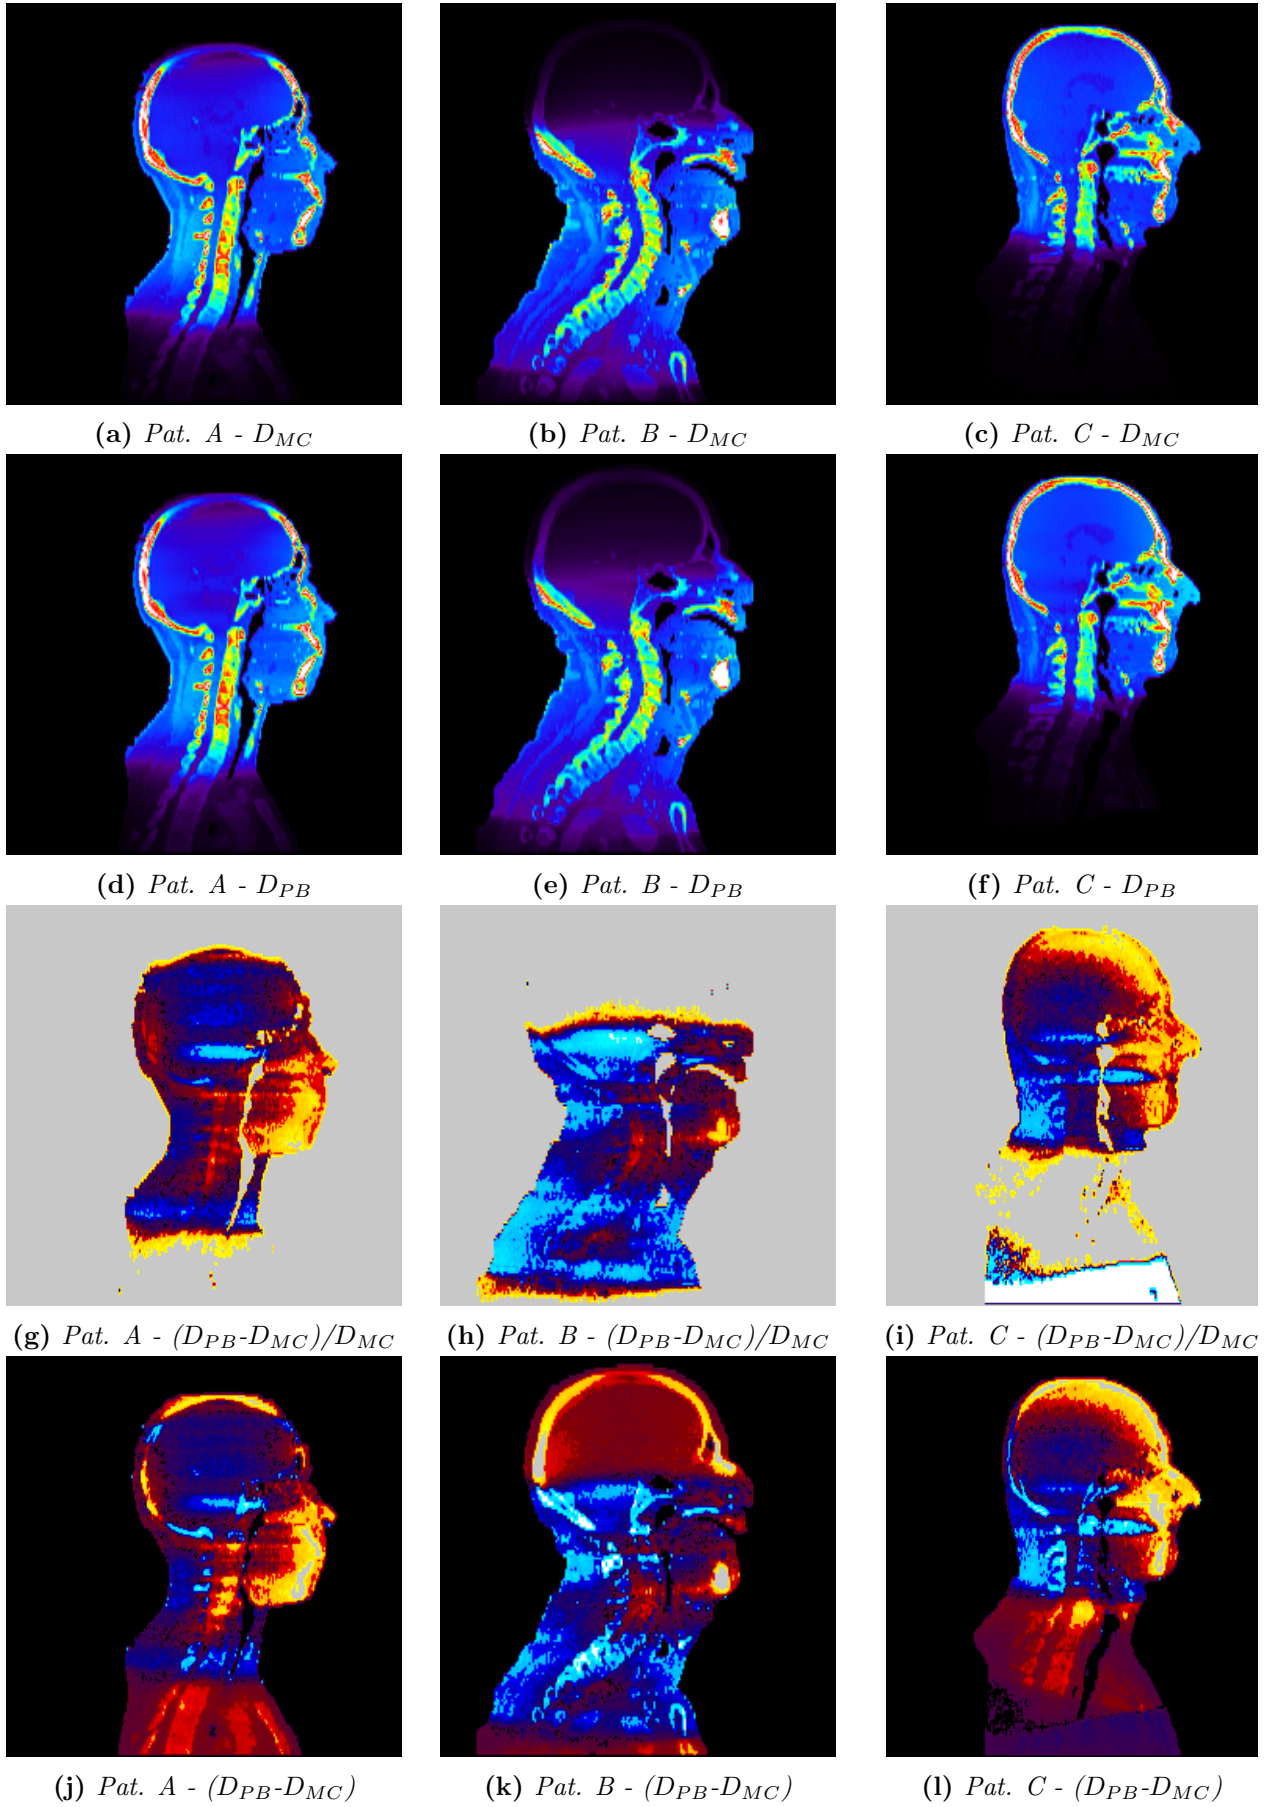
CBCT acquisition: Sagittal slices of the dose distributions and difference maps for all head and neck patients. The colorscales for this plot are shown in Figure 9.11.
